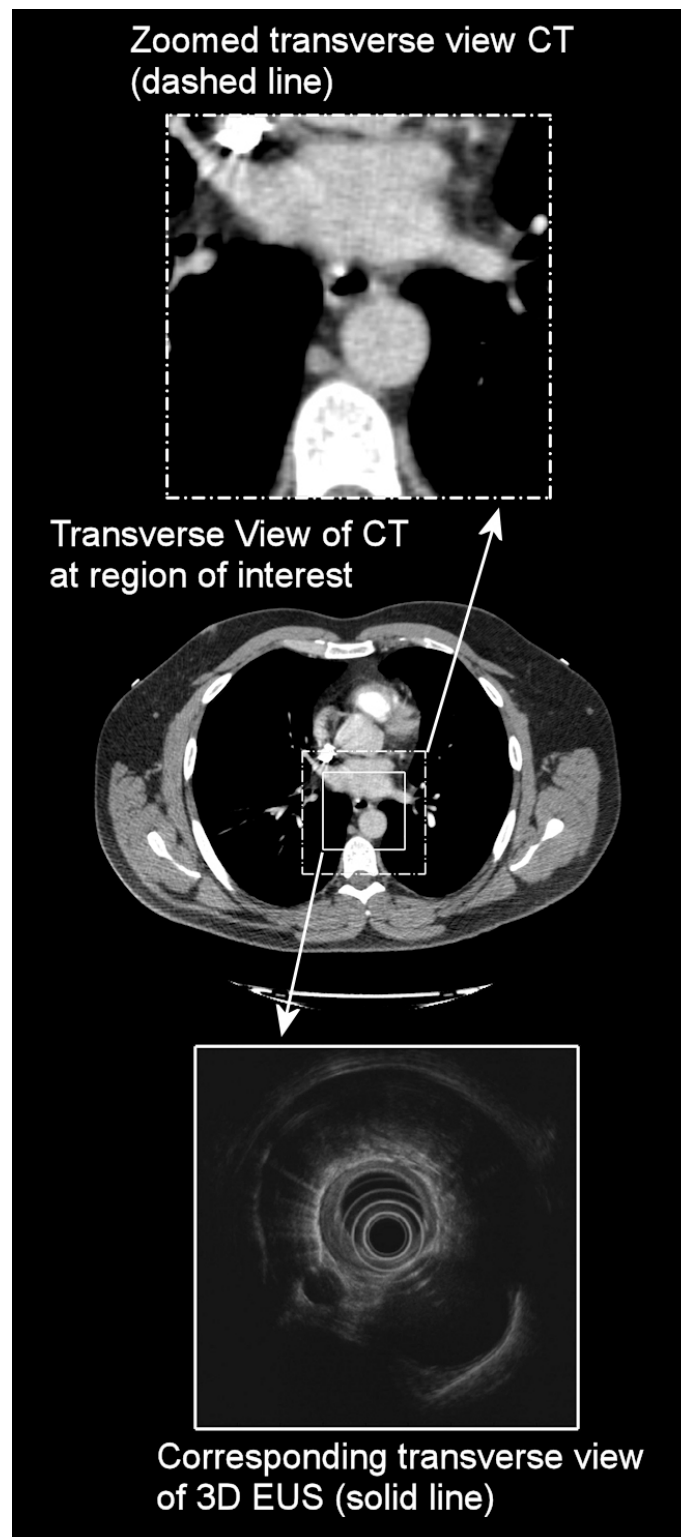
Comparison of transverse views between CT and 3D EUS, the transverse cuts of both CT and EUS are shown as 3.7cm below the bottom of the aortic arch. The EUS clearly showed an increase thickening of 6mm associated with tumour infiltration. The CT did not show any evidence of wall thickening.
